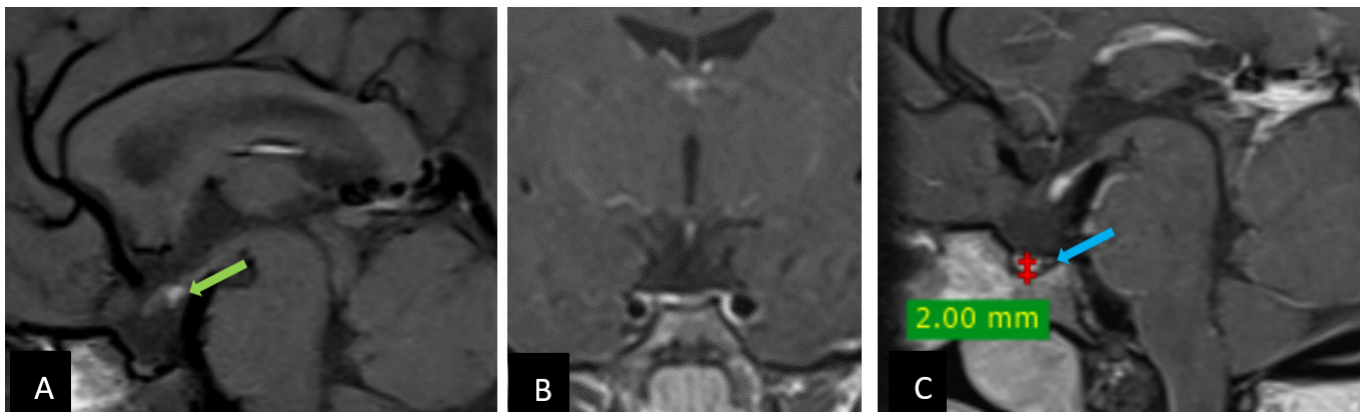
Hypothalamic-pituitary MRI of a 5 years old girl with short stature and growth hormone deficiency:
